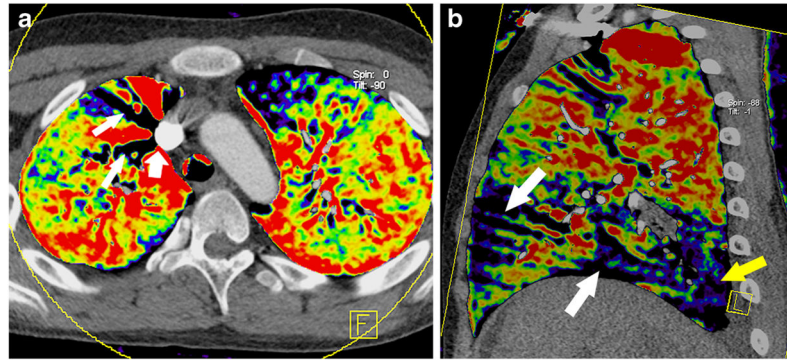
Common artifacts mimicking perfusion defects in dual-energy CT lung perfusion imaging in a 10-year-old boy with nephrotic syndrome. a–b Beam hardening artifacts and respiratory artifacts in dual-energy CT lung perfusion images. Radial beam hardening artifacts (*thin white arrows*) appear around vessels (*thick white arrow*) filled with contrast agent (a). Respiratory artifacts could be recognized in sagittal image as strip-shaped (*white arrows*) rather than wedge-shaped (*yellow arrow* in b)
